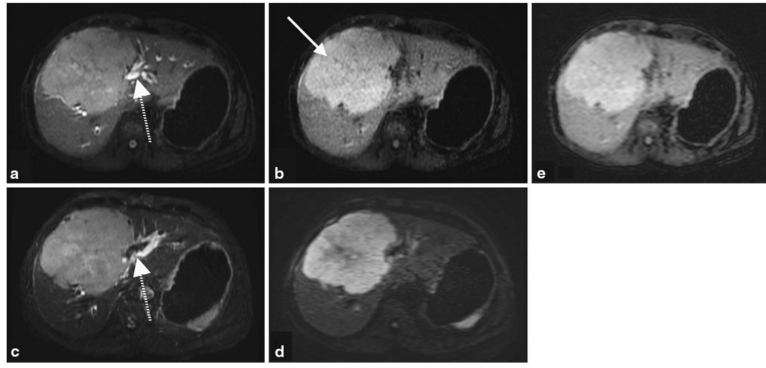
Shorter TE image (a) and the subtracted iSTIR image (b) of a patient with a large central liver mass (*arrow*), compared against fat-suppressed T₂-weighted image (c) and a diffusion-weighted image ($b = 500 \text{ s/mm}^2$) (d). Shorter TE image (a) resembles the fat suppressed T₂-weighted image (c), while the subtracted iSTIR image (b) qualitatively resembles the diffusion-weighted image (d). When reconstructed to the same spatial resolution as DWI, iSTIR image (e) provides equivalent contrast to noise ratio of DWI. The dashed arrow represents the biliary ducts that are visible on the shorter TE image (a) similar to the fat-suppressed T₂-weighted image (c). The final diagnosis of the tumor is aggressive poorly differentiated primary neuroendocrine cell carcinoma of the liver
